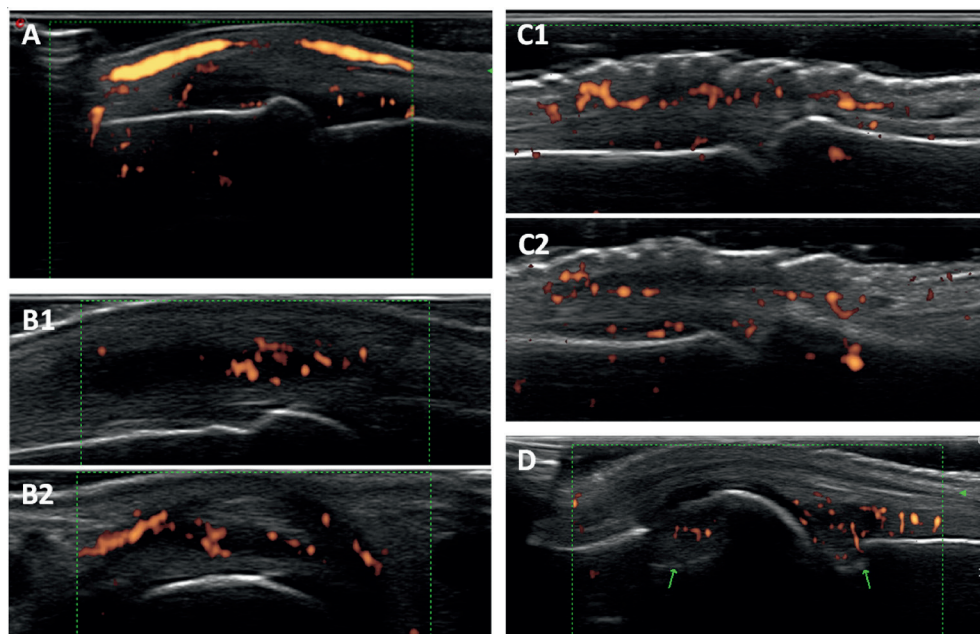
Examples of ultrasound (US) assessment of joint inflammation, focusing on (patho-)physiology potentially misclassifying inflammation by OST. Power Doppler was performed only if the gray scale synovitis score was positive, or in case of an obvious hypo- or anechoic lining adjacent to the extensor tendon. All joints visualized in longitudinal view, oriented with distal end on the proximal side. (A) Vascular pattern adjacent to extensor tendon, and synovitis of MCP 1; true positive classification. (B) Extensor tendinitis without synovitis of MCP 3; true negative classification. Two images from the same joint, first longitudinal scan (B1) inconclusive for tendinitis, therefore an additional transverse scan (B2) was made for objective scoring of extensor tendinitis. (C) Extensor tendinitis (specifically peritendinous vascularization) and synovitis of PIP 2; false negative classification. Two images from the same joint taken in slightly different longitudinal planes to focus on extensor tendinitis (C1) and synovitis of the joint (C2). (D) Active erosive synovitis (green arrows) and synovitis of MCP 1; false negative classification.
